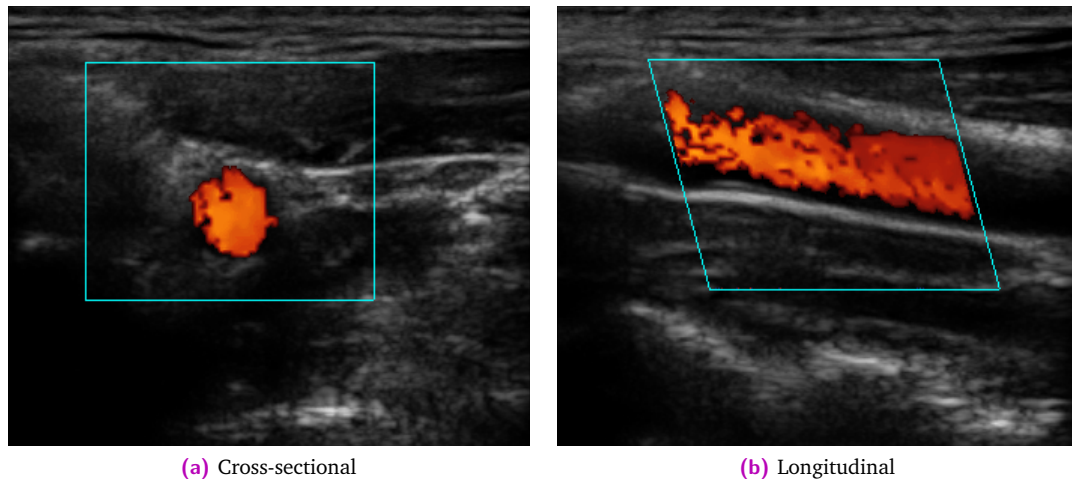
Exemplary color-coded duplex images of a healthy human carotid artery (male, 28), acquired with a linear probe in duplex mode during systole. The *cyan rectangle* indicates the Doppler window, where flow measurements are acquired and superimposed (*red* indicates flow toward the transducer, *blue* would signify flow away from it). Note that for the longitudinal scan (b), beamsteering was used to reduced the angle between the vessel and the US beam.
